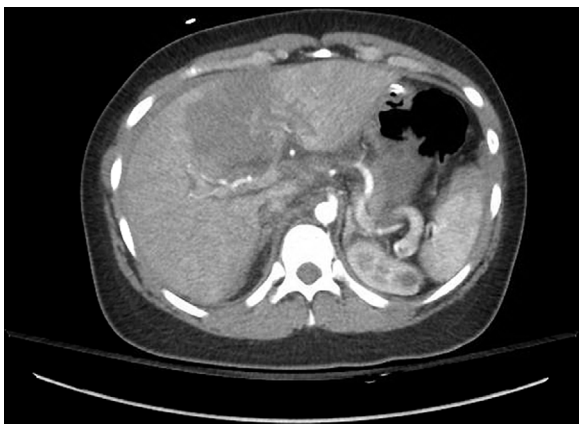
CT abdomen with 6.8 cm liver laceration.
